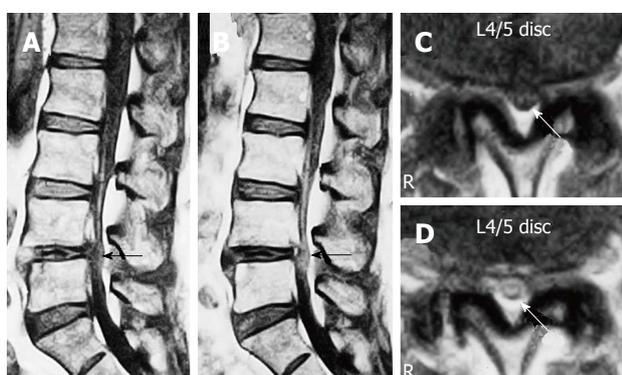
Gadolinium-enhanced magnetic resonance imaging of the cauda equina edema in lumbar canal stenosis. A 73-year-old man complained of weakness and numbness of the lower extremities after walking about 300 m, but no obvious sensory loss and muscle weakness was noted. Precontrast T1-weighted (500/35) sagittal (A) and axial (C) conventional spin echo MR image indicated a diagnosis of LCS at L4/5 disc level (arrows). T1-weighted (500/35) sagittal (B) and axial (D) Magnetic resonance image acquired at L4/5 disc level obtained after 0.1 mmol/kg intravenous Gd-DTPA administration showing the generalized central canal stenosis as well as punctate areas of intrathecal enhancement (arrows) indicating a breakdown in the blood-nerve barrier. Reproduced with permission from Kobayashi *et al*^[46].
